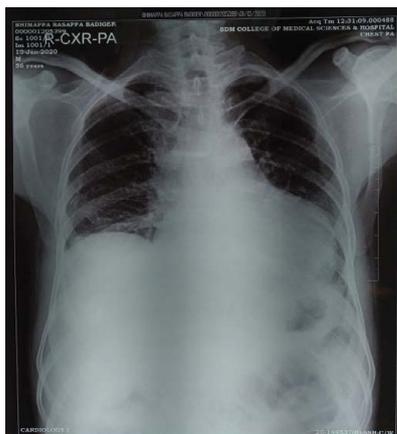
Chest X-ray showing cardiomegaly and clear lungs.
